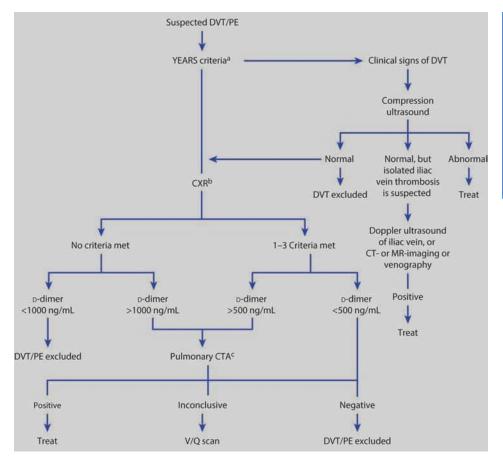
Algorithm to evalate suspected venous thromboembolism in pregnancy depending upon number of YEARS criteria met. Evidence of DVT should prompt compression ultrasound. ^aThe three YEARS criteria are clinical signs of DVT, hemoptysis, and PE as the most likely diagnosis. ^bThe American Thoracic Society and Society of Thoracic Radiology recommend CXR; 'The American Society of Hematology recommends pulmonary V/Q scanning. CT = computed tomography; CTA = computed tomography angiography; CXR = chest x-ray; DVT = deep-vein thrombosis; MR = magnetic resonance; PE = pulmonary embolism; V/Q scan = ventilation perfusion scan. (From Bates, 2018; Guyatt, 2012; Leung, 2011; van der Hulle, 2019; van der Pol, 2019.)
